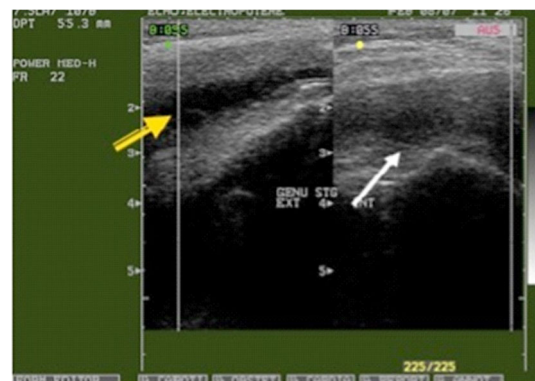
Two knee joint US images. In the right image, synovitis is shown in the knee joint (white arrow), while on the left US image, signs of fluid collection in the synovial sac of the knee can be noticed (yellow arrow). US: Ultrasound.
